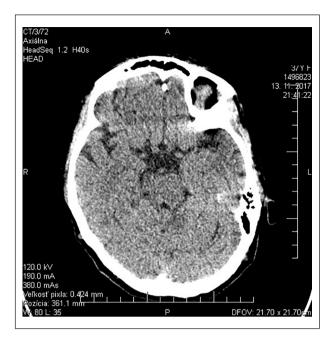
Negative brain computed tomography at admission.
